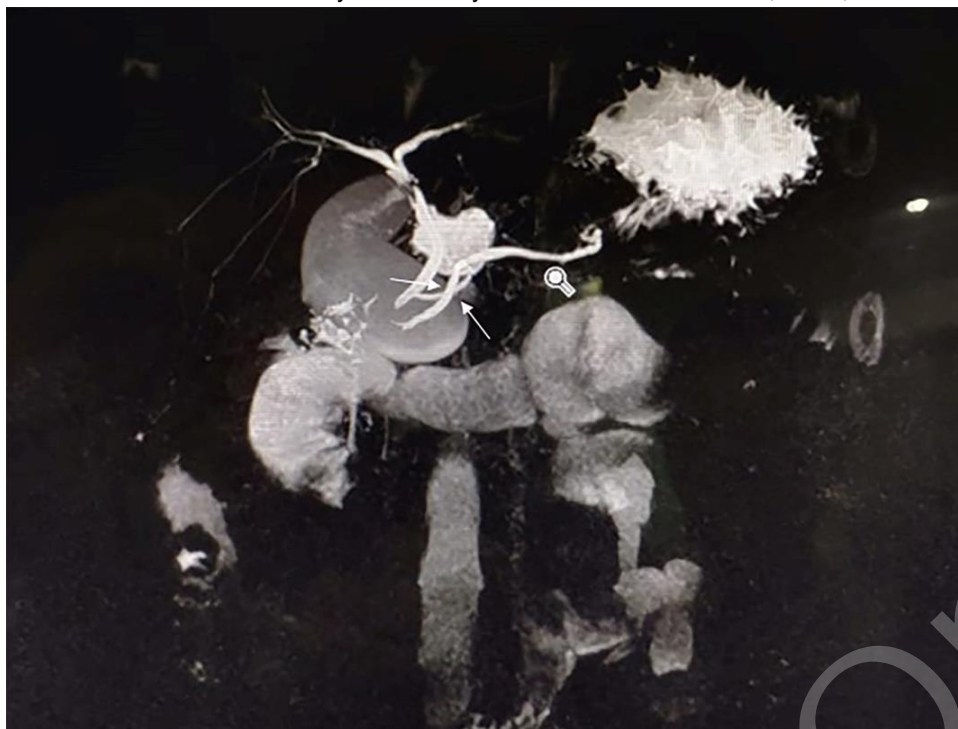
Magnetic resonance imaging exhibiting Ansa Pancreatica. Magnetic resonance cholangiopancreatography displays a looping duct in the pancreatic head (white arrows) opposed to a conventional accessory duct. On this image, the additional duct can be spotted crossing the main pancreatic duct.
